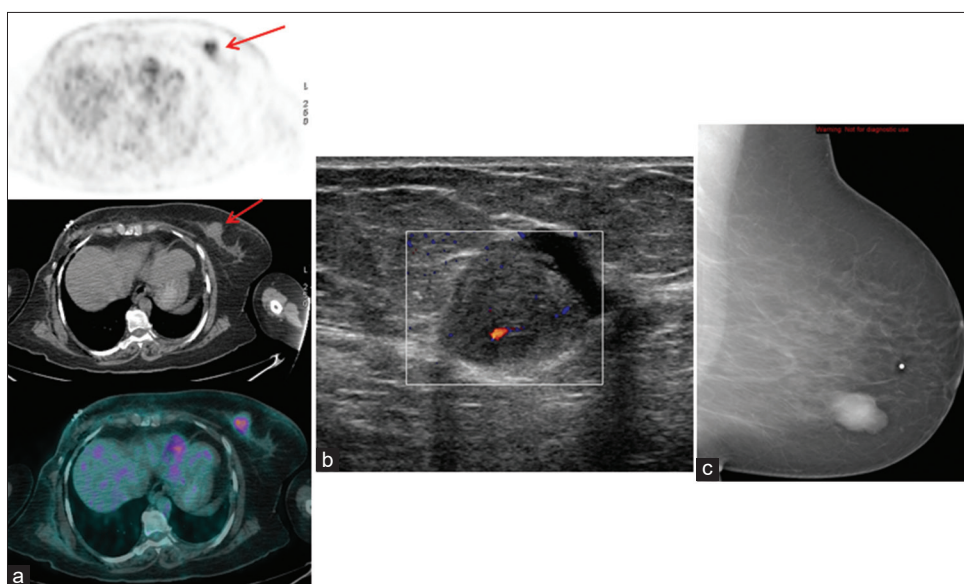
A 54-year-old female with a history of right breast carcinoma post modified radical mastectomy (MRM) restaging positron emission tomography/computed tomography (a) revealing left breast hypermetabolic lesion with maximum standardized uptake value of 7 (red arrows), ultrasound (b) revealing well-circumscribed hypoechoic lesion (2.5 cm x 2.0 cm), most of the lesion is solid with the exception of its anterior component, with increased vascularity on the color Doppler, Her mammogram revealed a well-circumscribed oval mass in the inner lower quadrant (c). Excisional biopsy revealed intraductal papilloma with florid ductal hyperplasia
